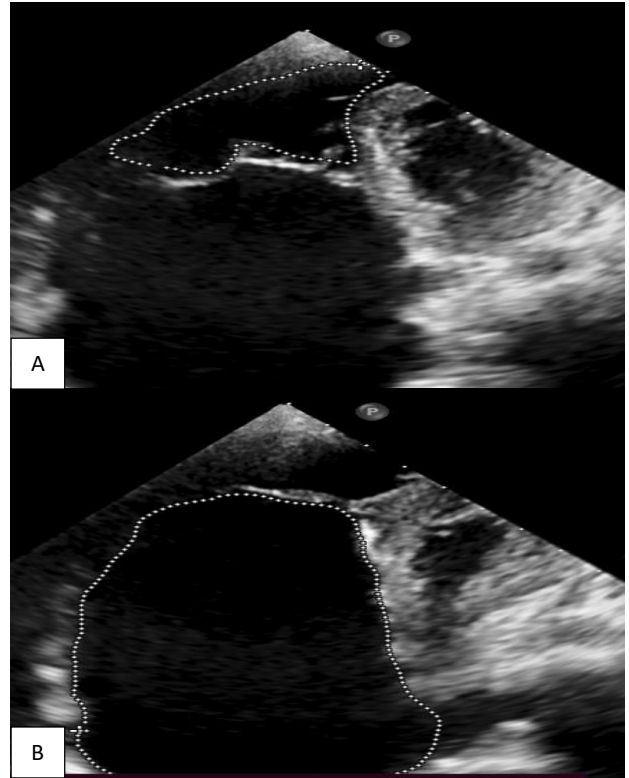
(A and B): Transthoracic 2D echocardiogram of functional RV area and combined RA and aRV area.
